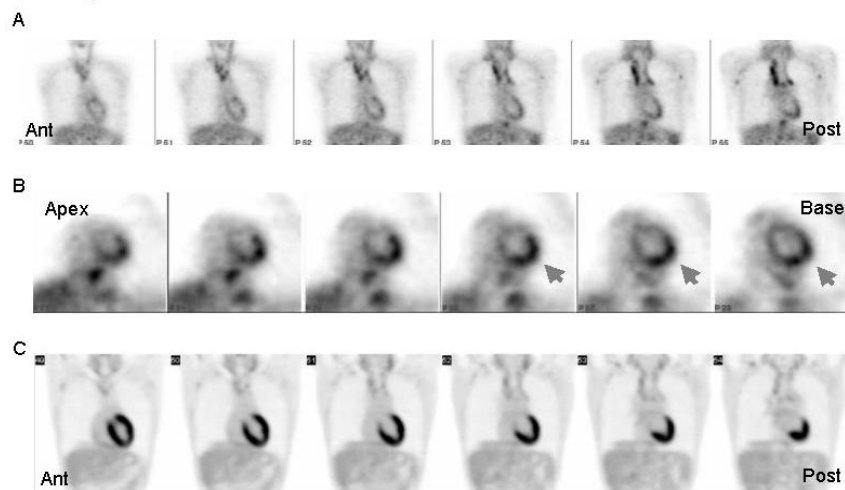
Coronal FDG-PET images (A) obtained before steroid therapy showed increased uptake in the mediastinal and bilateral axillary lymph nodes. Short-axis slices of the heart (B) indicated increased uptake in the lateral to inferior wall (*arrow*). Follow-up FDG-PET performed one year later (C) showed decreased uptake in the mediastinal and bilateral axillary lymph nodes, and a marked increase in uptake in the whole heart. All images are expressed using the same scale of SUV of 0.0 to 5.0.
